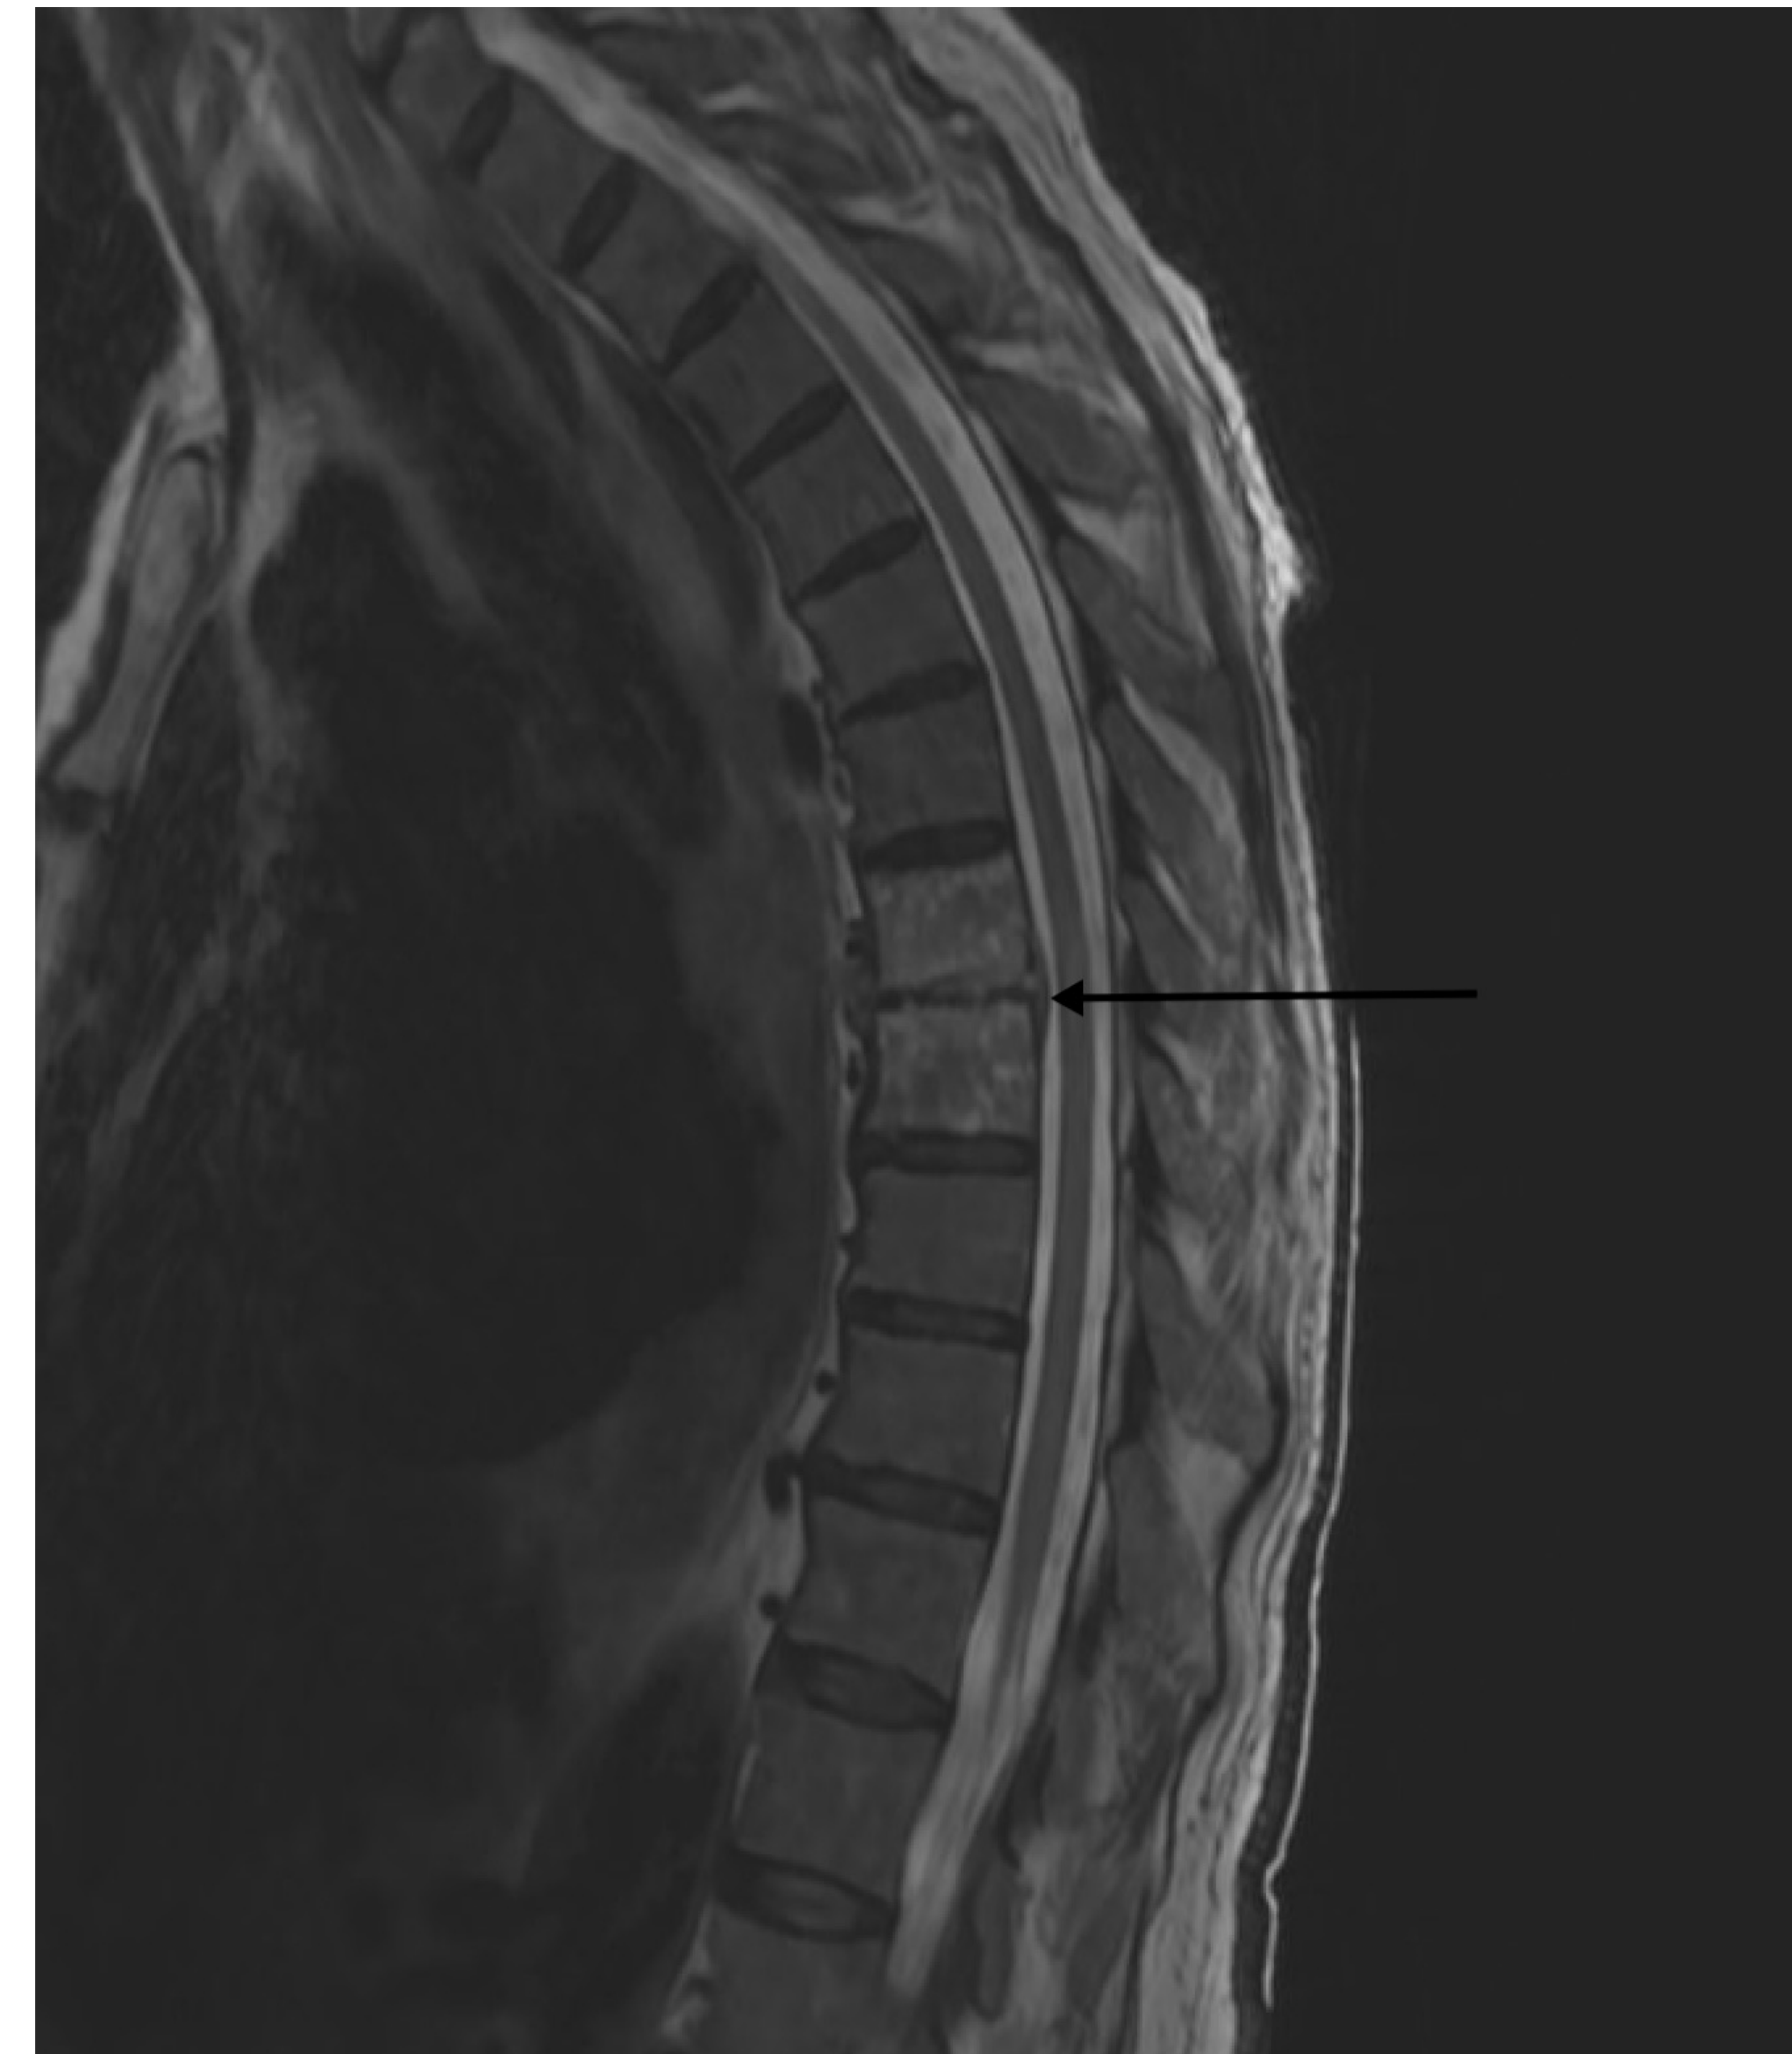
MRI demonstrating marrow signal changes and enhancement of the thoracic 7 and 8 vertebral bodies with mild marrow signal abnormality extending to the posterior elements. Paraspinal soft tissue signal change is seen with edema, minimal fluid and enhancement, and extending to the ventral epidural space. The arrow points to the area of discitis/osteomyelitis
